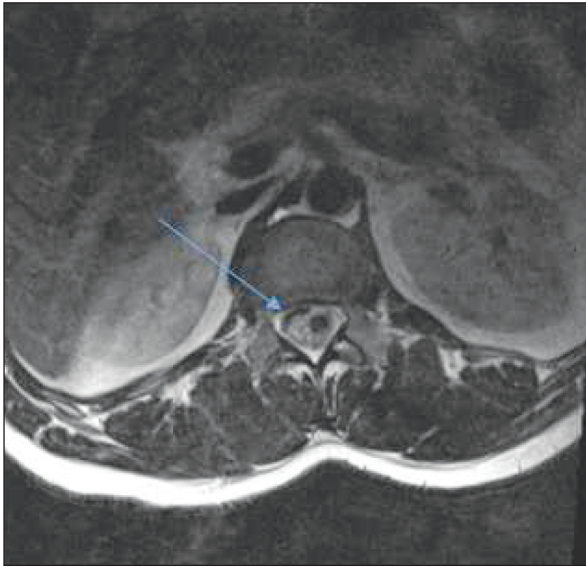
Spinal cord compression on MRI
